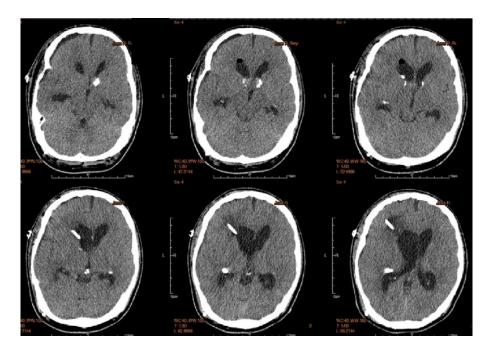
Post-operative cranial CT Scan, axial;.* There is no residual mass as previously identified with marked decrease in the size of the ventricles. A shunt is in place with tip at the right lateral ventricle.
